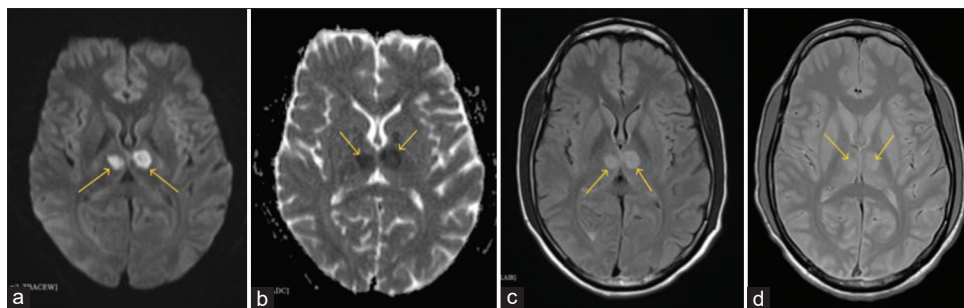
Magnetic resonance imaging (a and b) Lateral medial thalamic diffusion restriction (a) with ADC reversal (b-d) FLAIR and T2W image shows bilateral medial thalamic hyper-intensity
